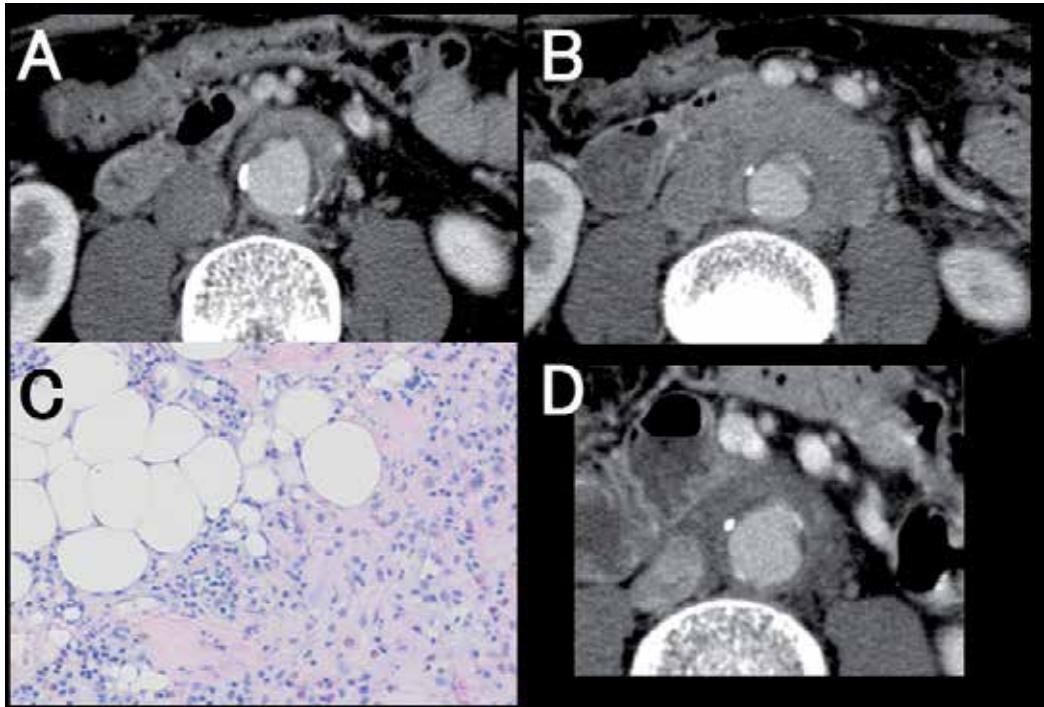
A case of chronic periaortitis with retroperitoneal fibrosis. A 75-year-old man presented with vague discomfort of lower abdomen. Panel A was at presentation. Two months later the symptoms remained unchanged with 8.5mg/dL of C-reactive protein but without fever. Repeated CT was performed (Panel B). Biopsy of the tissue revealed the infiltration of inflammatory cells and no bacteria (Panel C). Panel D was three weeks after the glucocorticoid therapy.
